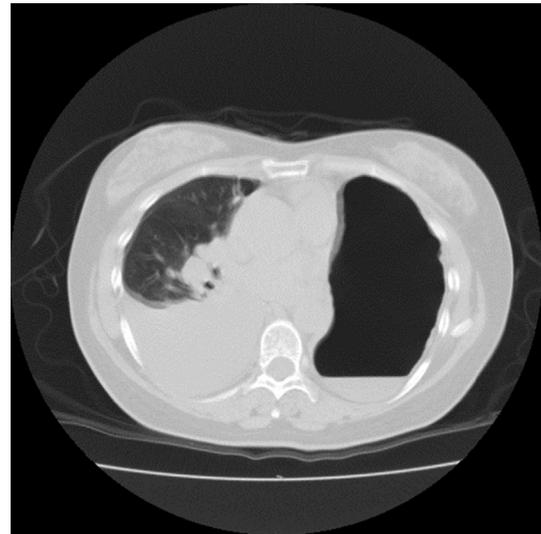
Computed tomography (lung window) showed the stomach is herniated at the left lower mediastinum secondary to diaphragmatic defect.
